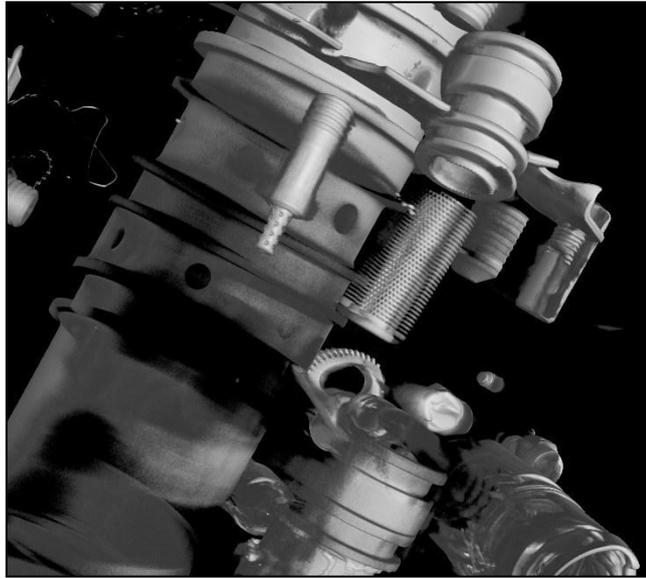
CT Scan - Input Strainer (PVM-1)
